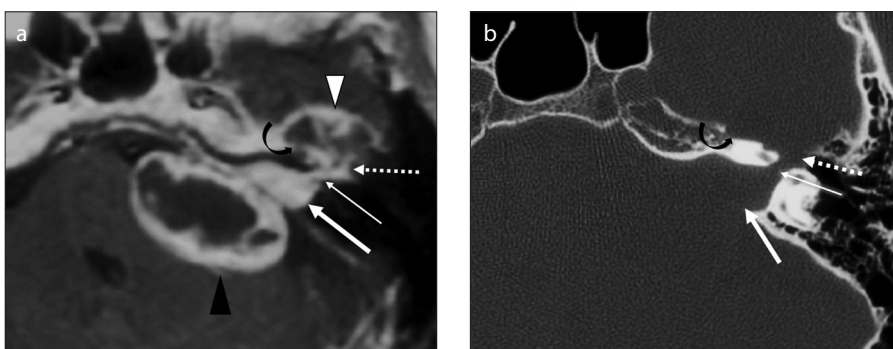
a, b. Contrast-enhanced axial T1-weighted image (a) and axial HRCT image (b) show a dumbbell-shaped FNS on the left side. The FNS is involving the CPC segment (a, black arrowhead), IAC segment (a and b, thick white arrow), labyrinthine segment (a and b, thin white arrow), and the GG (a and b, dotted white arrow). It is extending to the middle cranial fossa (a, white arrowhead) through the widened facial hiatus. Note its extension along the course of GSPN (a and b, curved black arrow). On HRCT axial image (b), the margins of the expanded FN canal appear smooth and well-defined without cortical destruction.
